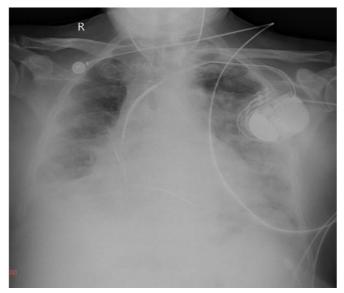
Chest x-ray of the patient at ICU
